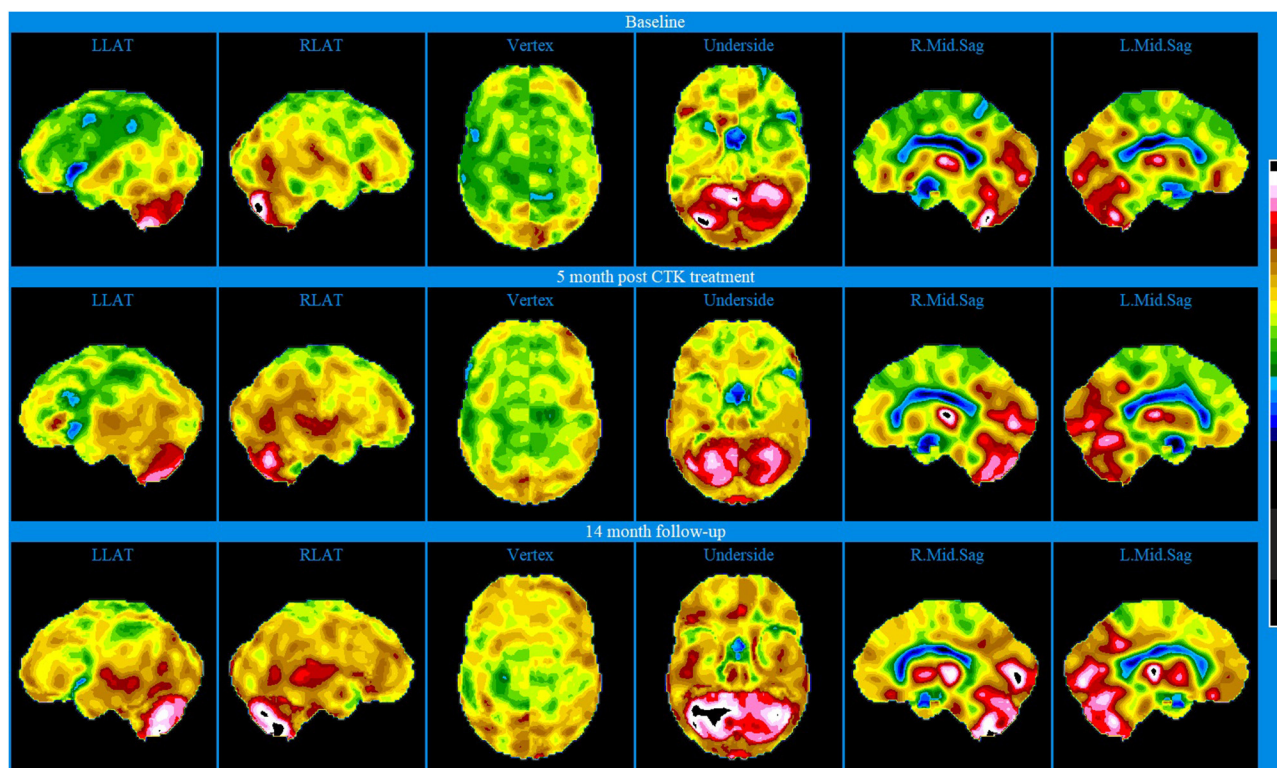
Brain SPECT stereotactic surface projections for Patient III. Top line relates to brain SPECT images at baseline. Middle line shows SPECT images 5 months after the first CTK treatment. Bottom line shows SPECT images 14 months following CTK treatment. In each row (from left to right) six stereotactic surface projections of LLAT, RLAT, Vertex, Underside, right mod sagittal, and left mid sagittal.
